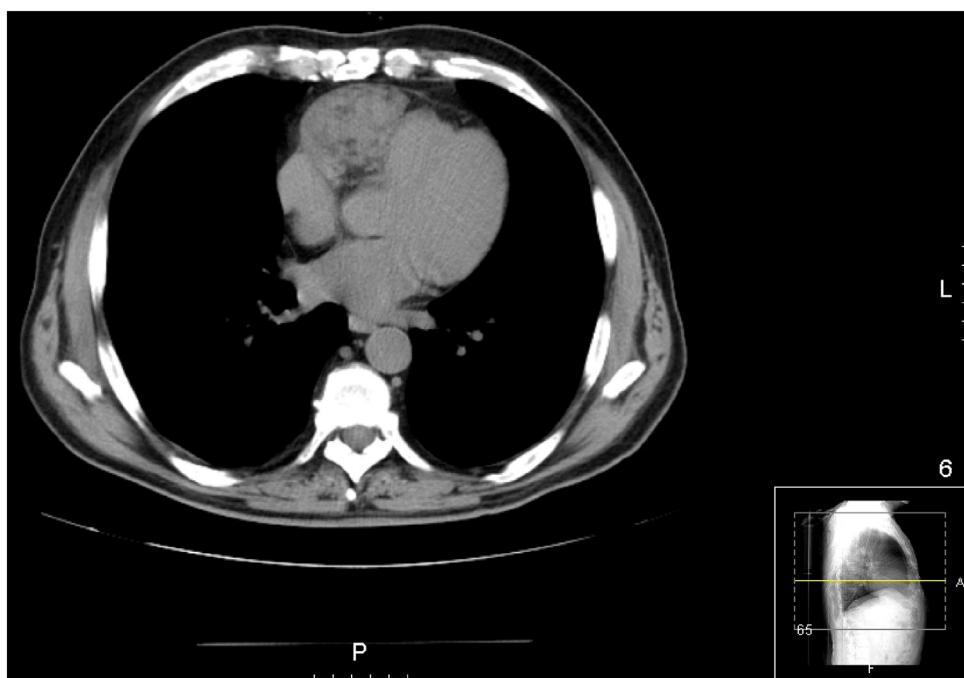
Computed tomography scan of the chest showing the right lateralized mass (asterisk), beginning in the antero-superior pericardium up to the right atrium (white arrow) and right ventricle (dotted arrow).
